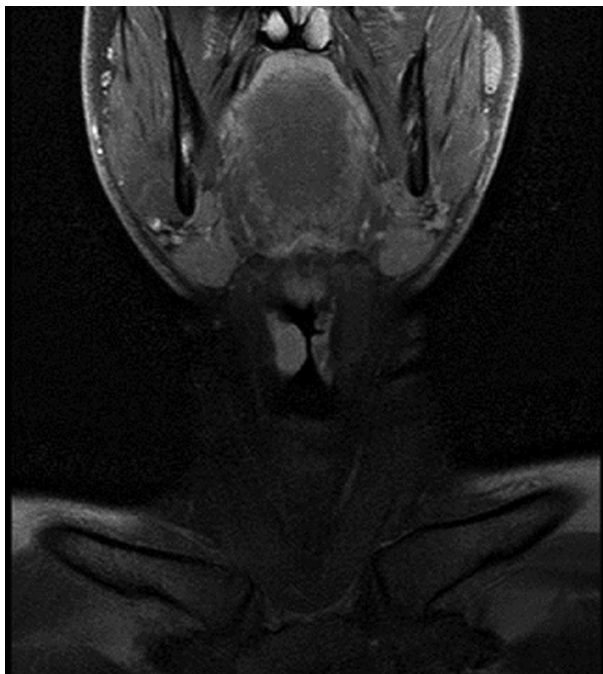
MRI Coronal T1W postcontrast showing the thickening of the right true vocal fold.
